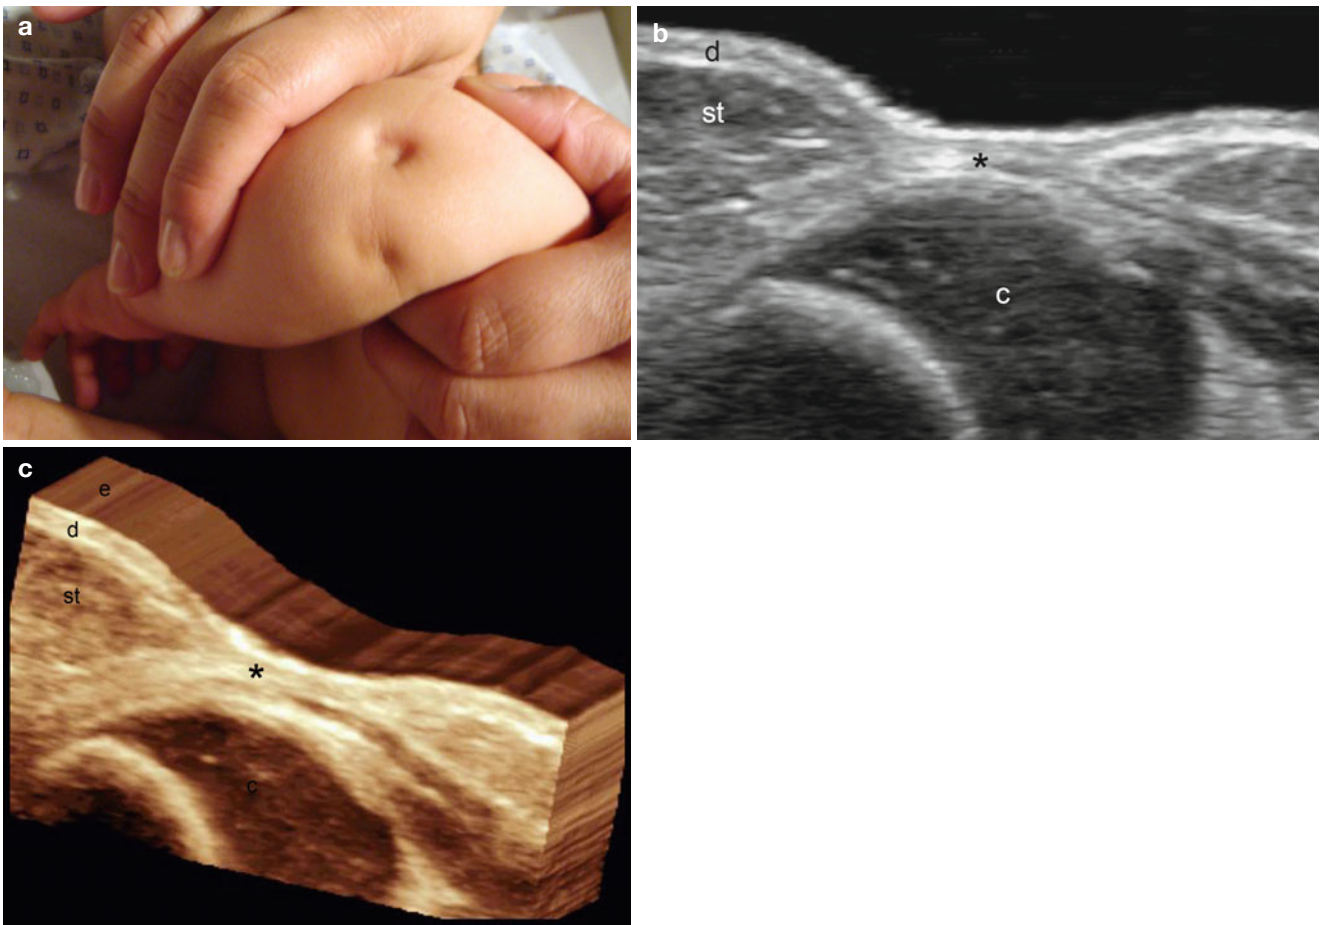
(a–c) Aplasia cutis. (a) Clinical image of the lesional area showing two depression sites at the posterior aspect of the left elbow. (b) Ultrasound image (longitudinal view) demonstrates a focal lack of subcutaneous fatty tissue in the lesional area (*). Notice the close
